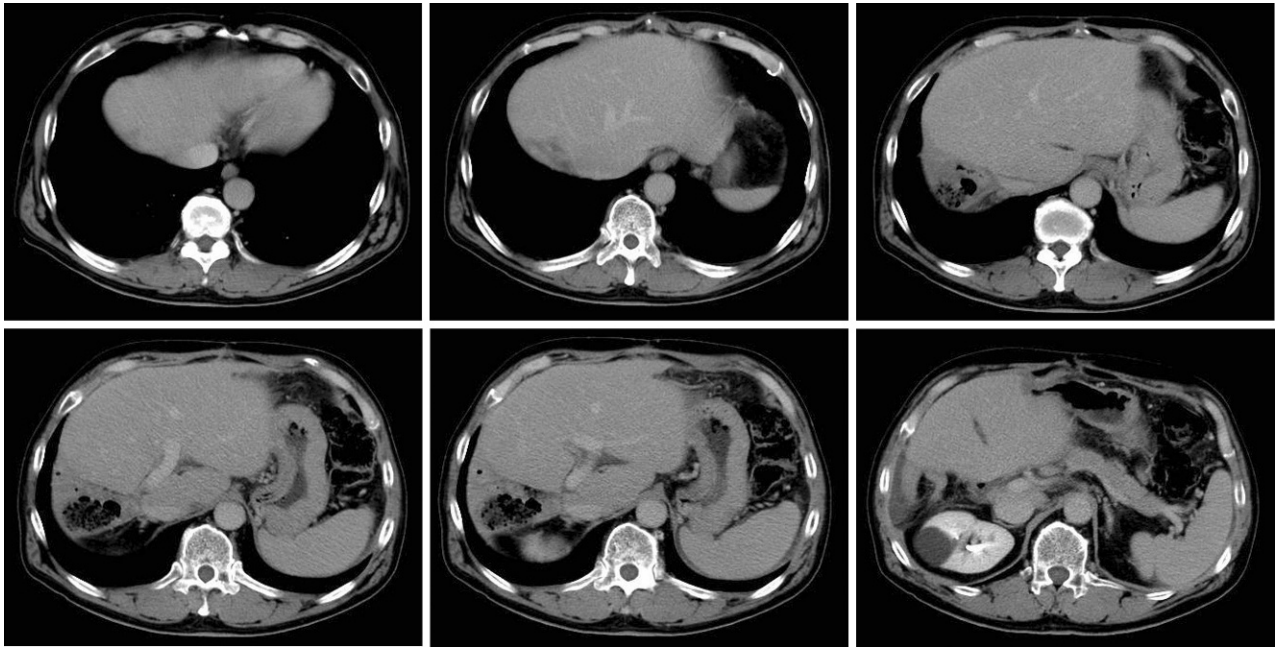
Abdominal computed tomography revealed no liver metastases postoperatively.
